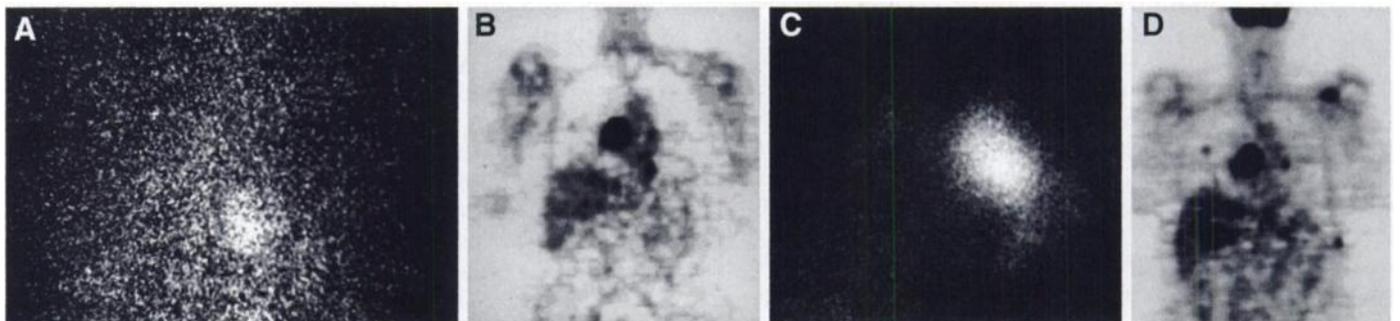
Mediastinal metastasis shows marked increase in radioiodine uptake after redifferentiation therapy. (A) Radioiodine scan of thorax, posterior view, before treatment with retinoic acid; thyroid-stimulating hormone (TSH): 25 $\mu\text{U}/\text{ml}$; radioiodine amount: 1.1 GBq. (C) Identical view as A after treatment with retinoic acid; TSH: 38 $\mu\text{U}/\text{ml}$; radioiodine amount: 11.1 GBq. FDG PET revealed high glucose utilization values in mediastinum, lung metastases, left shoulder and 10th rib (left side). (B) Coronal FDG PET slice, patient's left side is on the right, before retinoic acid treatment. (D) Identical slice as B after treatment with retinoic acid.
